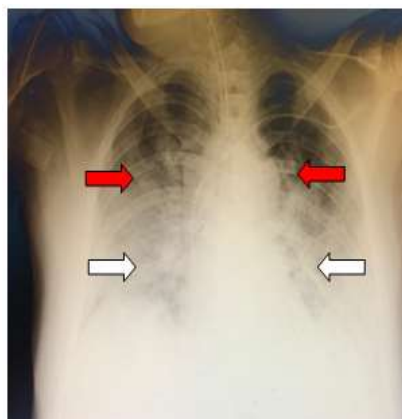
Chest X-ray of a 56-year-old male patient (same patient) with positive RT PCR for Covid-19 and had received a vaccine injection 6 months earlier (14 days later). Patient died. Note: red arrow: infiltrates; white arrow: ground-glass opacity.
